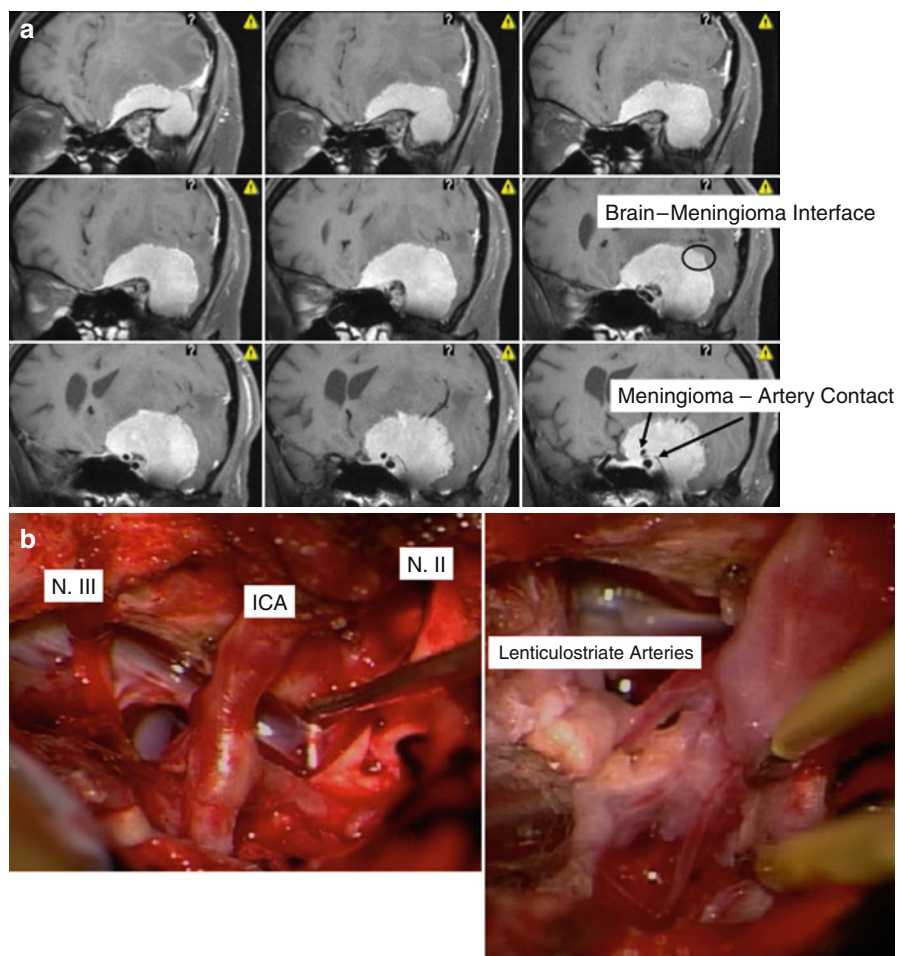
(a) Surgeon's questions to MRI: Tumor interfaces with brain, nerves, and vessels. Neuroradiology can only partially help. (b) Surgeons' view: The tumor is easily peeled off the internal caroid artery (ICA) and nerves I-II but not from perforators
